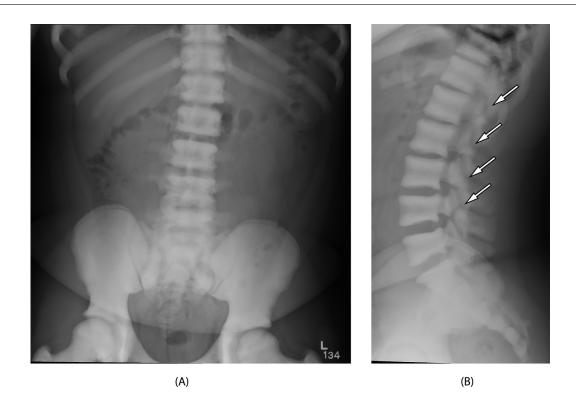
Radiographs of lumbar spine in child with osteopetrosis and multilevel spondylolysis. (A) Frontal radiograph shows severe diffuse bony sclerosis and (B) Lateral radiograph again shows severe diffuse bony sclerosis. There is spondylolysis (arrows) demonstrated as linear lucencies through the pars at multiple levels.
